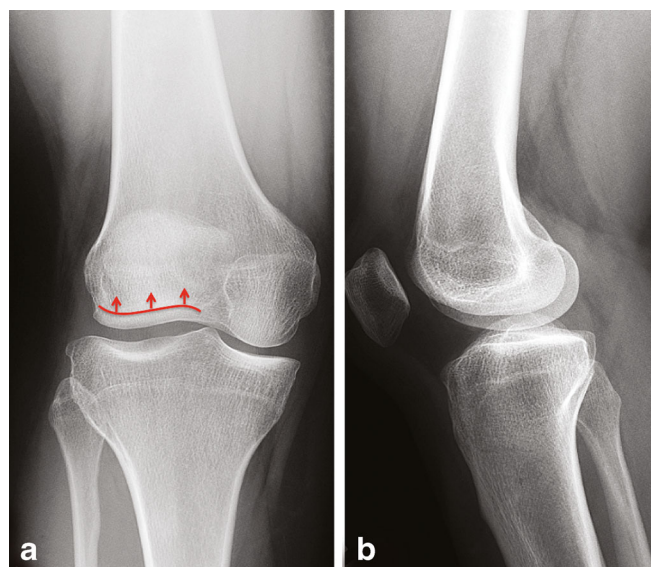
Plain radiographs. a PA view. b Lateral view. Depressed lateral tibial plateau and a hypoplastic lateral femoral condyle (*red arrows*).
